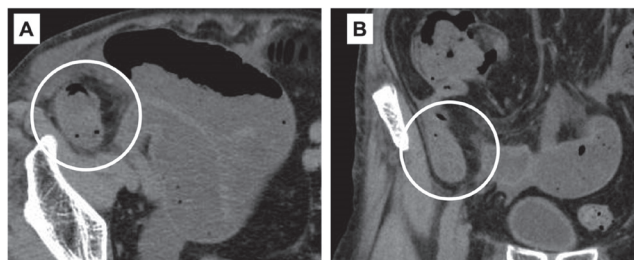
Abdominal CT scan showing dilated small intestine incarcerated with peritoneum in the right inguinal region with dilation of the intestine proximal to that site.
